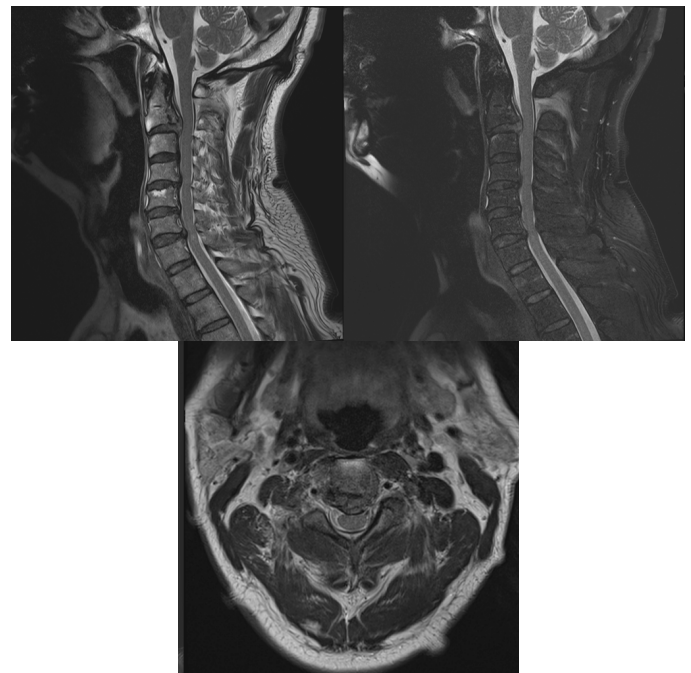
MRI demonstrates translation of the second and third cervical vertebrae accompanied by intervertebral disc protrusion.
